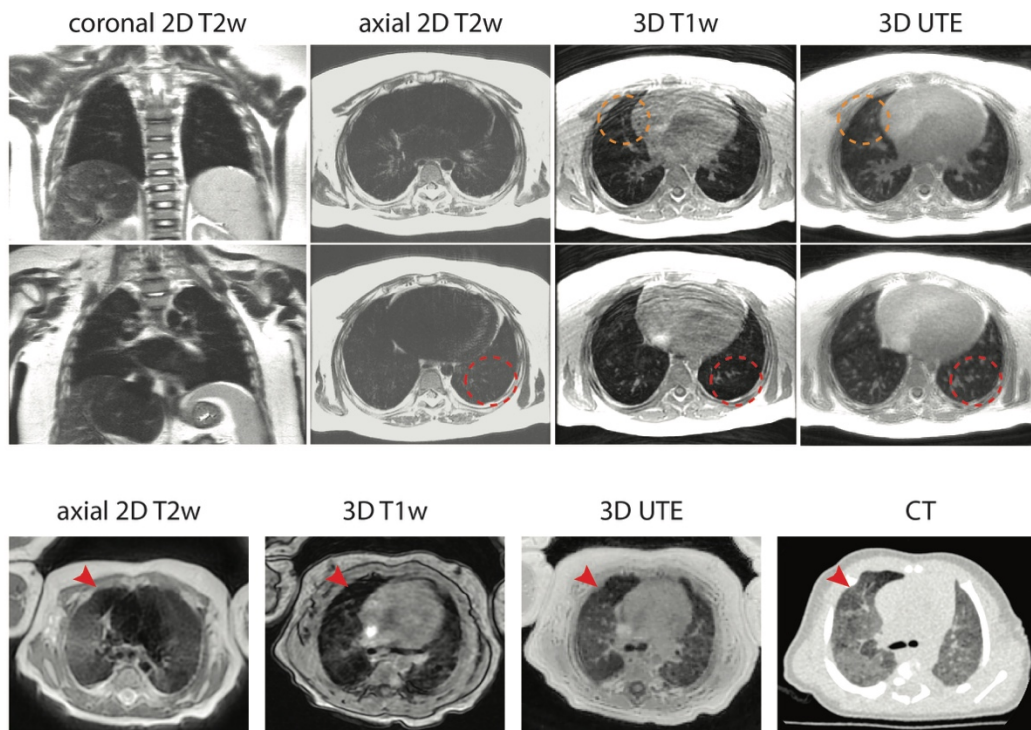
MRI sequence images comparison in the lungs. Two SSFSE T2w sequences with navigator based respiratory gating, one axial 3D GRE breath-hold sequence, and the optimized UTE sequence images from one pediatric patient are compared (top two rows). UTE images showed higher SNR (dashed red circle) and were more robust to motion (dashed orange circle) compared to other sequences. In the bottom row, the axial PROPELLER FSE T2w sequence, the axial 3D GRE sequence, the optimized UTE sequence, and a CT scan are compared. The air trapping area (red arrows) shows hypointense in both CT and UTE images.
